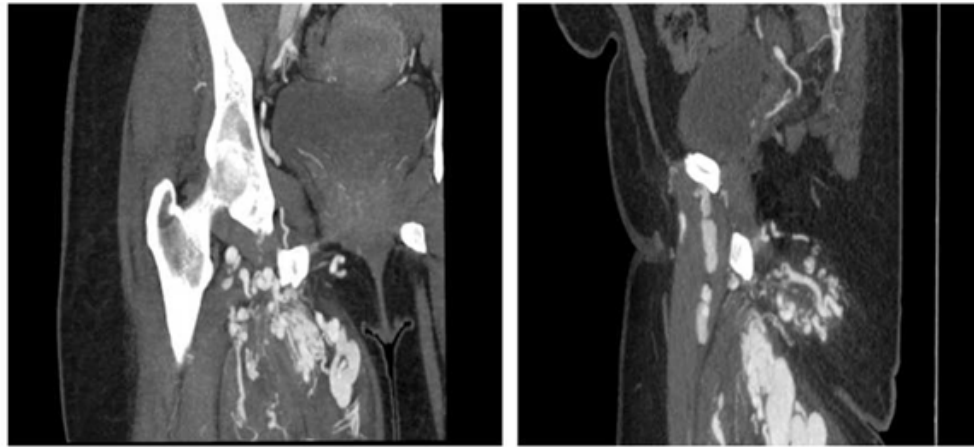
Coronal and sagittal reconstruction. CT angiography shows a complex intramuscular AVM, with multiple feeding arteries from right internal iliac artery, right common femoral artery, right superficial femoral artery and right profunda femoris artery.
